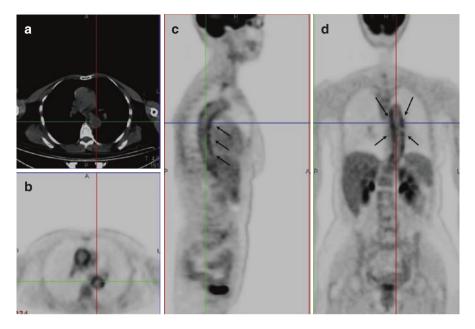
FDG positron emission tomography (PET)-computed tomography-(CT) in a case of thoracic aortitis. (a) Shows a non-contrast-enhanced CT of the chest (axial view) and (b) the corresponding PET image, the latter showing hypermetabolism in both the ascending and descending aorta. In the same patient, whole-body PET images in (c, d) (sagittal and coronal views, respectively) show increased FDG uptake along the thoracic aorta (arrows)
